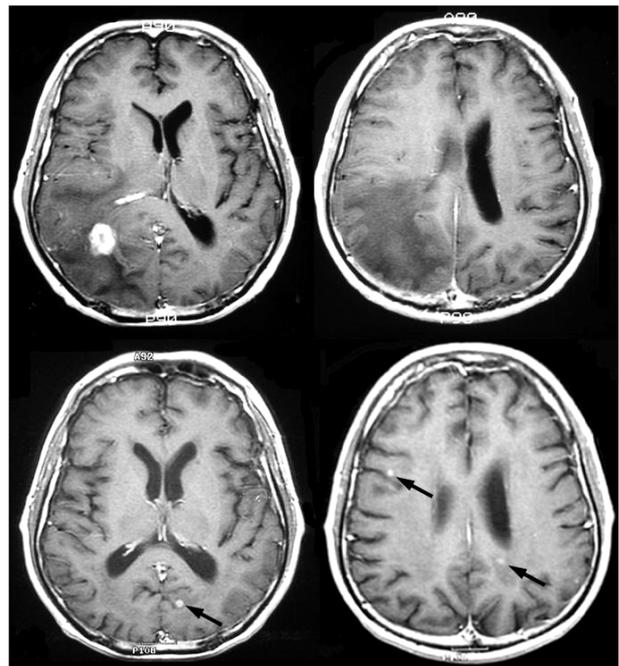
Axial T1-weighted MR images with Gadolinium enhancement. Upper : At the time of 1st GKS images shows a metastatic lesion with peritumoral edema on right parietal lesion. Lower : Follow up image of 3 months after GKS showed reduction of previous treated lesion and peritumoral edema, but multiple new lesions were emerged (black arrow). May be they were too small to be visualized on MRI at the time of GKS, so we called invisible lesion.
